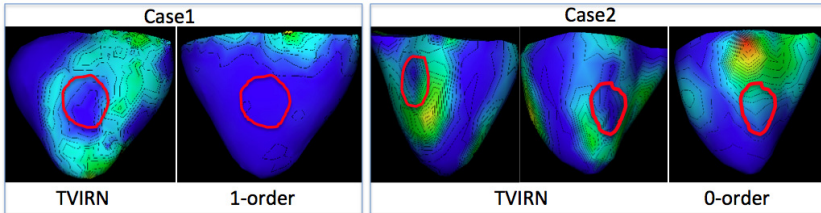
Spatial gradients of transmural action potentials reconstructed from TVIRN and quadratic methods on two post-infarction human hearts. The red cycles represent the core of the MRI-delineated infarcts.
